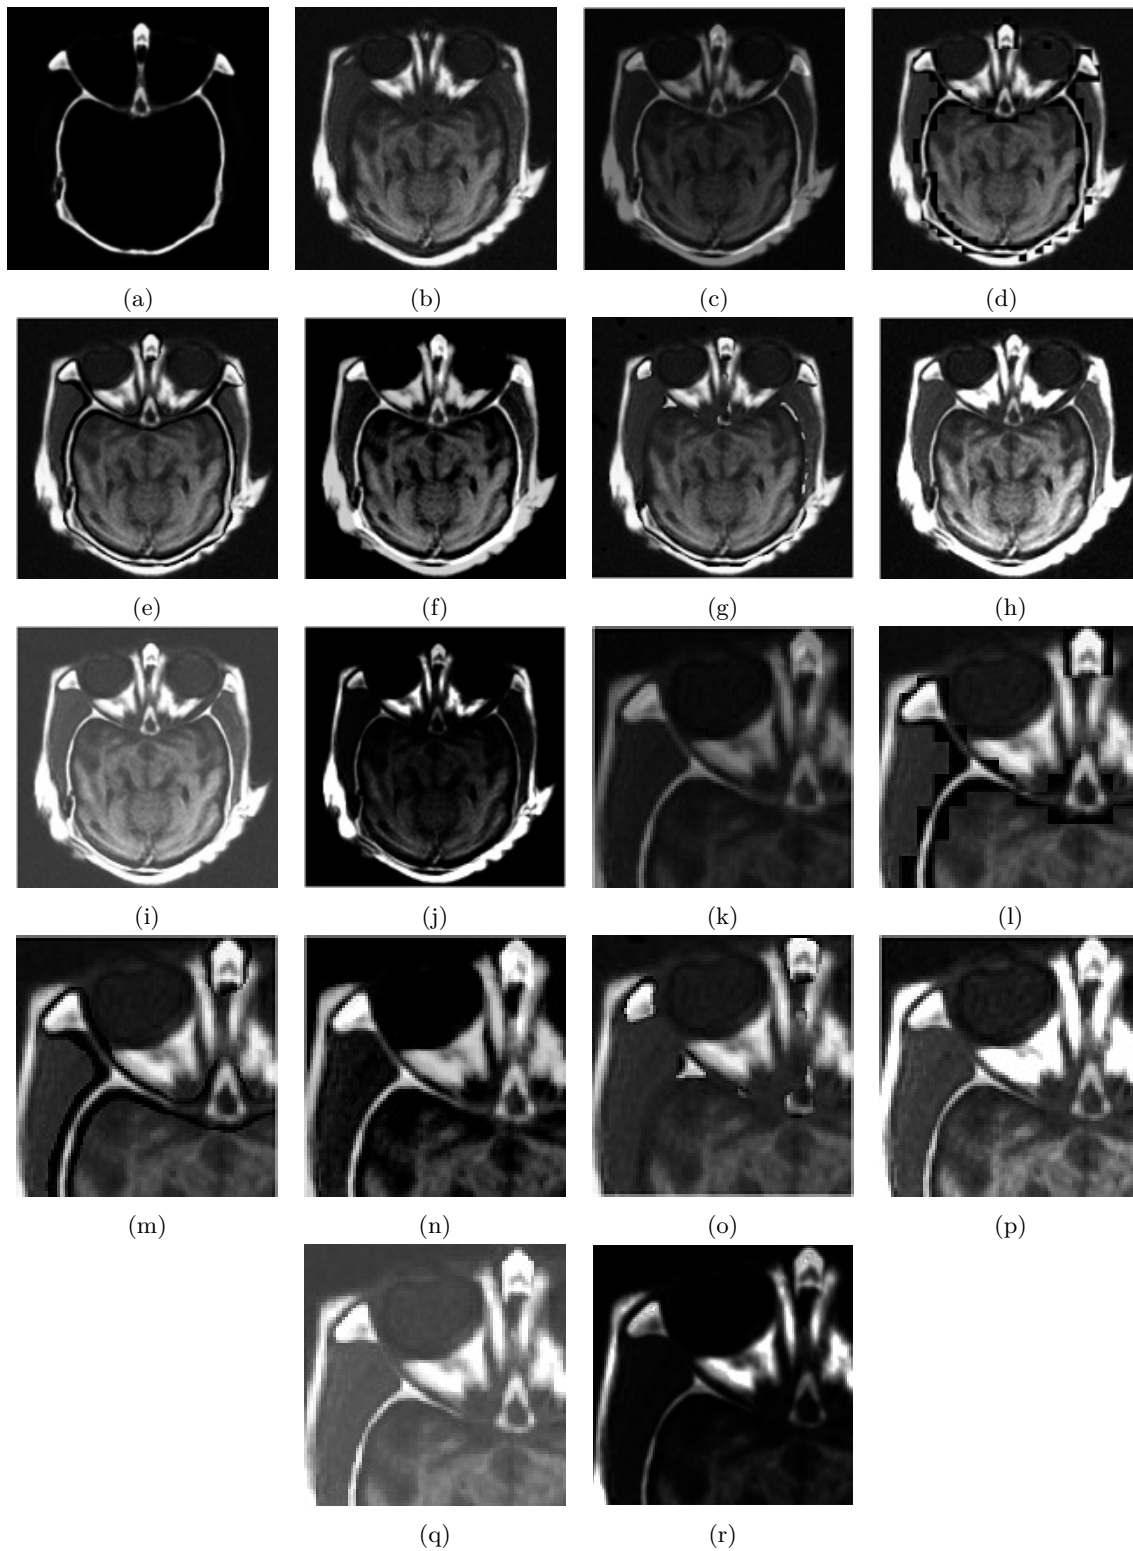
Fusion results for CT and MRI images. (A) CT image (B) MRI image (C) Fused image by simple average (D) Fused image by DCT (E) Fused image by RWT (F) Fused image by Intuitionistic fuzzy set (G) Fused image by Fuzzy transform (H) Fused image by proposed method (I) Fused image by Interval-valued intuitionistic fuzzy set (J) Fused image using Yue Entropy [38] (K), (L), (M), (N), (O), (P), (Q), (R) are the magnified results of (C), (D), (E), (F), (G), (H), (I) and (J) respectively.
